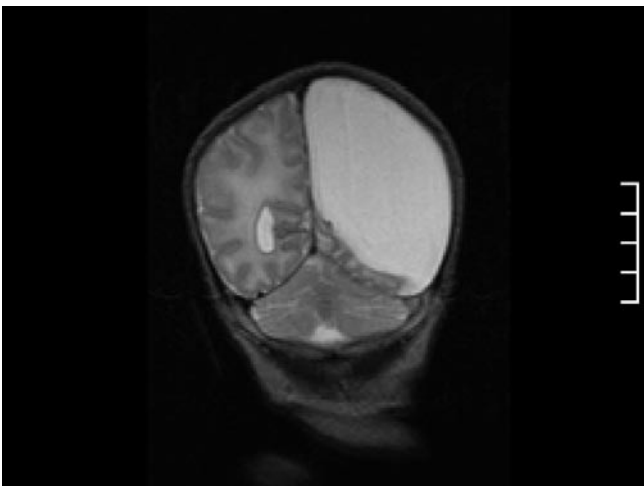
Coronal postnatal MRI demonstrating cystic mass posteriorly.
